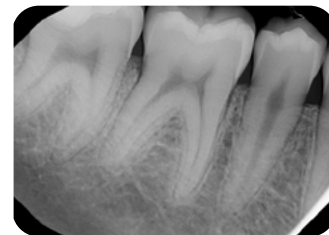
2023: Radiograph of tooth #31. Two year follow-up. Teeth remained vital and asymptomatic post operatively at subsequent follow up appointments. No evidence of the progression or recurrence of decay noted.
